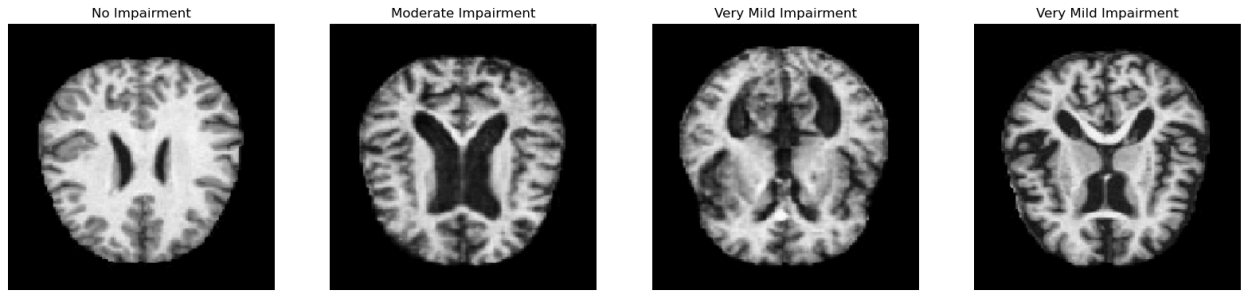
Sample MRI images from each class in the dataset
